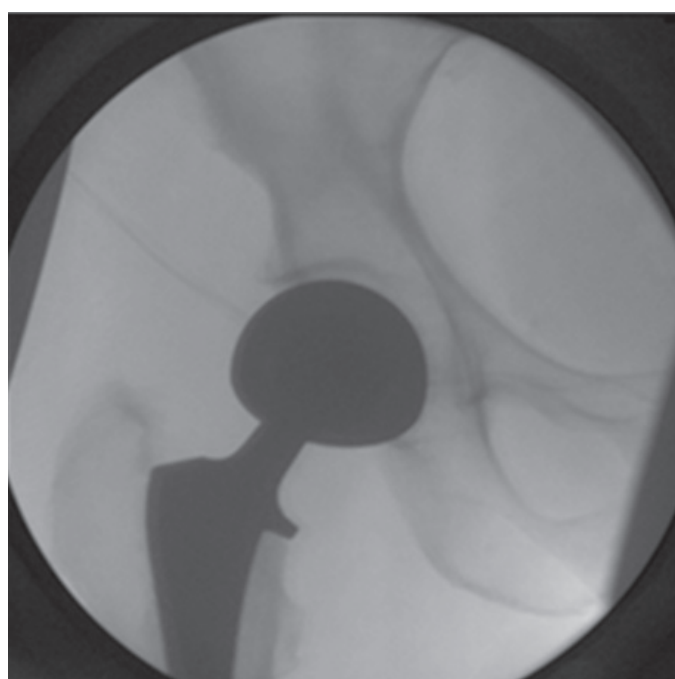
Radiograph of right hip post-reduction on fracture table. Hip is reduced.
